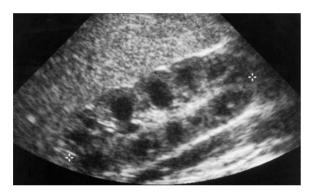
Sonogram of a 2-month-old girl. Sagittal view of the right kidney. Typical sonographic appearance with increased cortical echogenicity, prominent, relatively anechoic pyramids, reduced dense central sinus echoes and grooves on the surface
